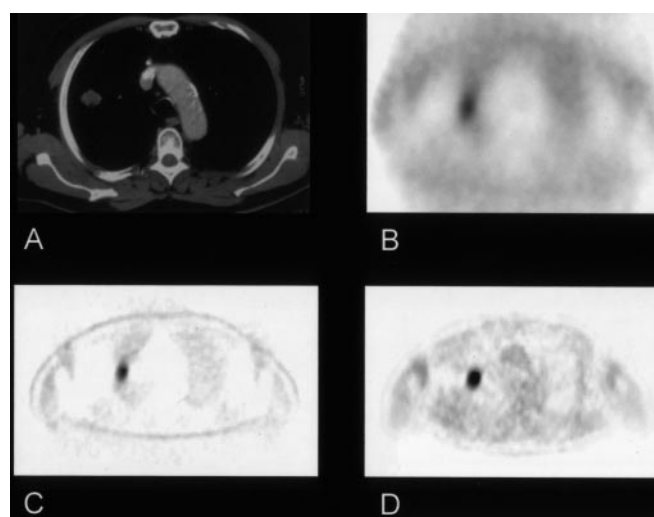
CT (A) CGC (B), PETnac (C) and PETac (D) studies of a patient with a squamous cell carcinoma (patient 16). The tumour shows markedly increased FDG uptake that is clearly visualized on the CGC, PETnac and PETac images. However, background activity is considerably higher on the CGC images than on the PET images
